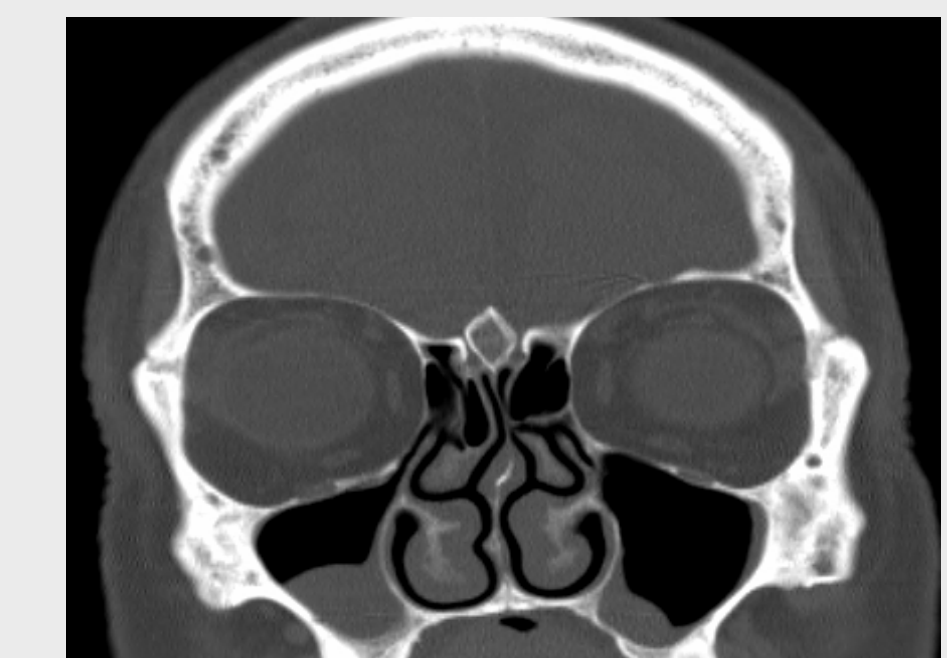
CT scan prior to treatment.
